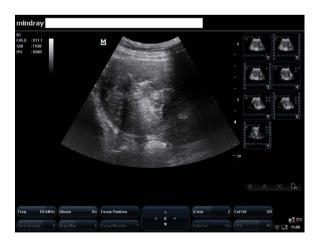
Ultrasonographic image of the fibroid after RF
